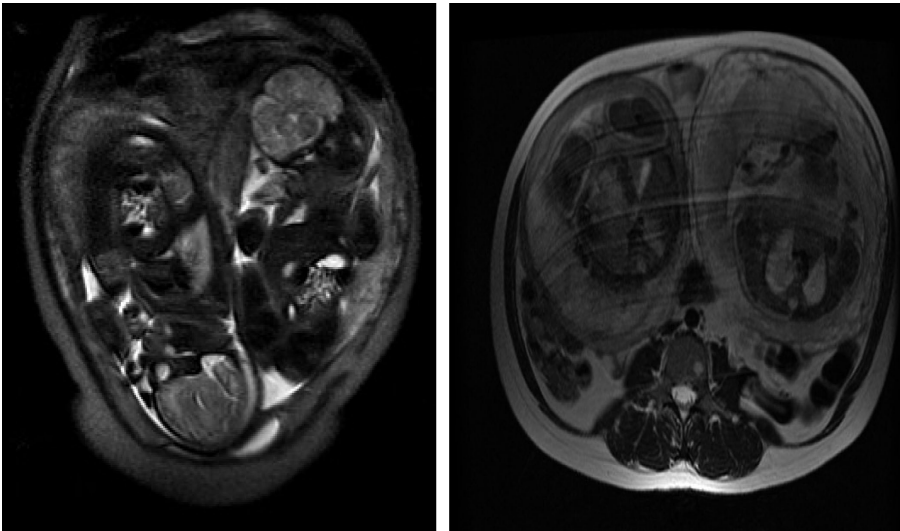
A) T2-weighted abdominal image (coronal plane) showing simultaneous 34-week pregnancy in each horn of a uterus didelphys in a 29-year-old woman. B) T2-weighted abdominal image (axial plane) showing simultaneous 34-week pregnancy in each horn of a uterus didelphys in the same patient.
